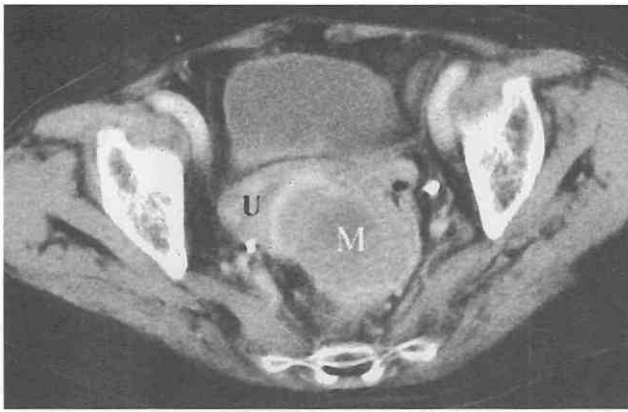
Rectal cancer with uterine invasion. CT scan shows a large heterogeneous rectal mass (M) with compression and direct invasion into the posterior wall of the uterus (U).
